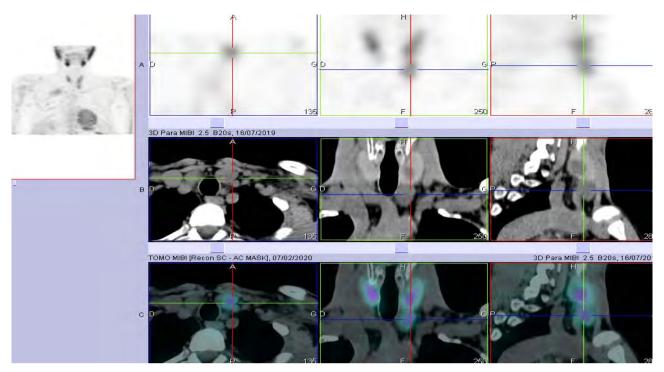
SPECT/CT showing an ectopic parathyroid adenoma behind the left sterno clavicular joint.
